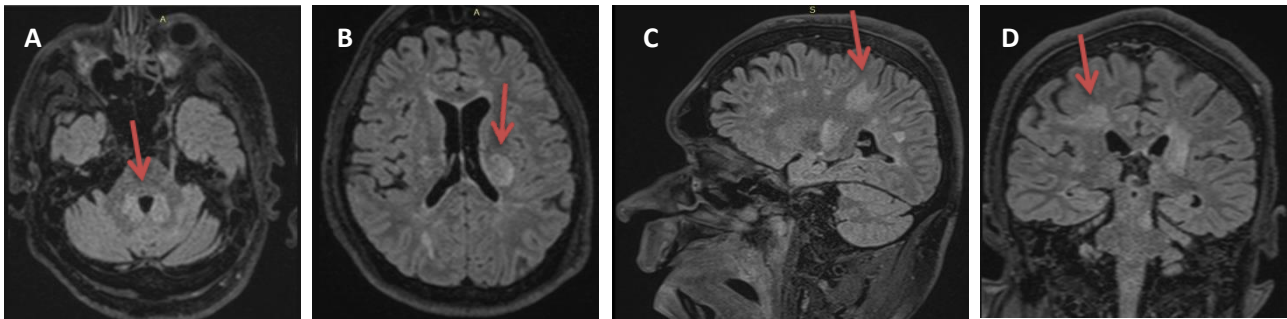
Brain MRI in May 2021 after intubation. A: New demyelinating lesions (red arrow) in the cerebral peduncles bilaterally. B: New demyelinating lesion in the periventricular white matter bilaterally, the largest one on the left (red arrow) C: New large demyelinating lesion (red arrow) in the white matter of the right parietal lobe. D: Large demyelinating lesions in the corticospinal tracts bilaterally and in the white matter of the right parietal lobe (red arrow).
